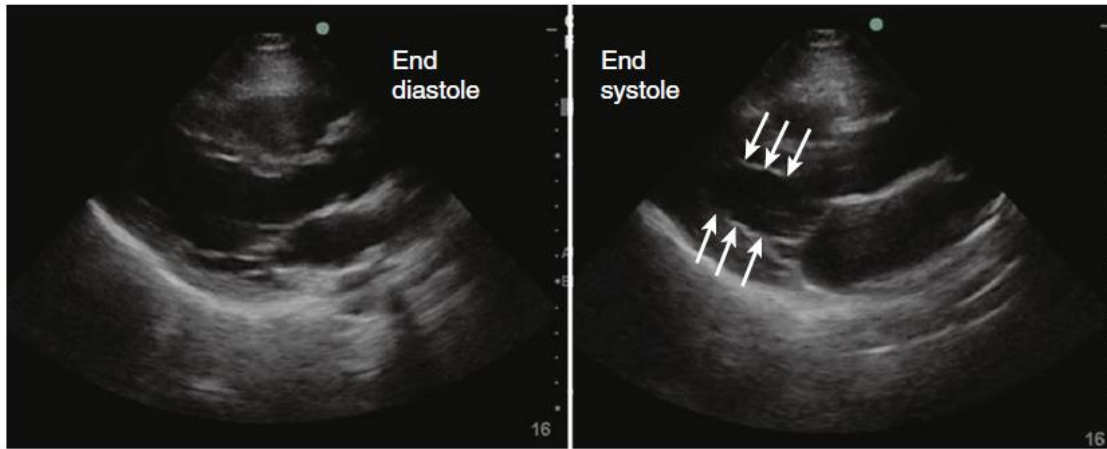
Parasternal long-axis view showing normal excursion of the left ventricular (LV) walls during systole. Endocardial resolution is excellent in this view, and thickening and excursion of LV walls can easily be appreciated.
